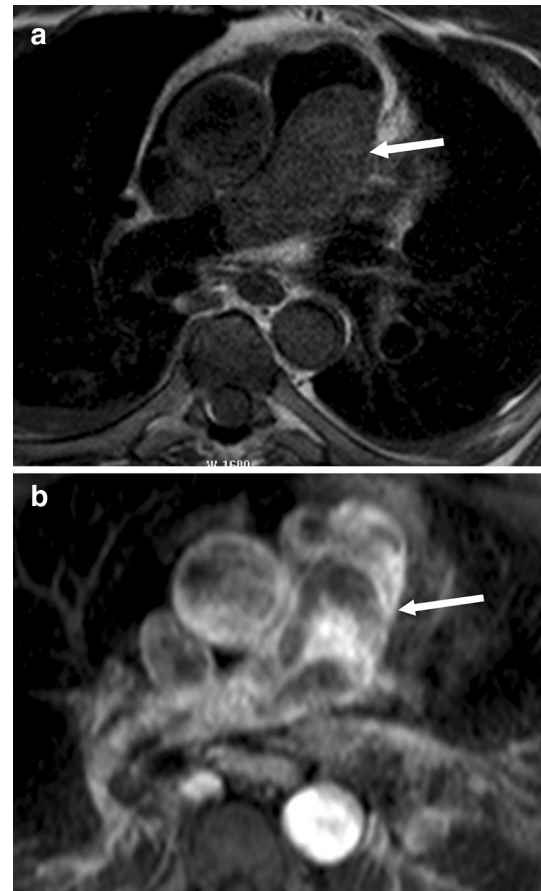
Neoplasm. a Axial pre-contrast T1-weighted image shows a large hypointense mass (arrow) in the main pulmonary artery that expands the artery, b contrast-enhanced T1-weighted image shows intense heterogeneous enhancement of the mass (arrow), which is consistent with a sarcoma
